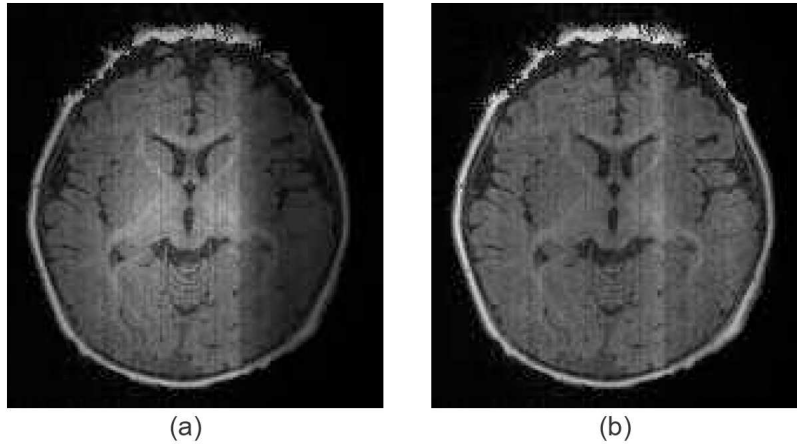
A sample MRI scan (a) before and (b) after bias correction.
